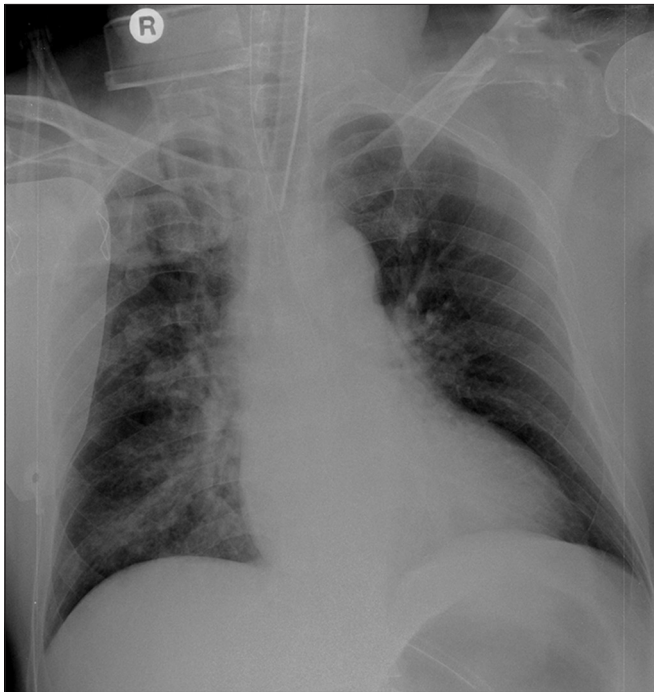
Frontal chest radiograph.
